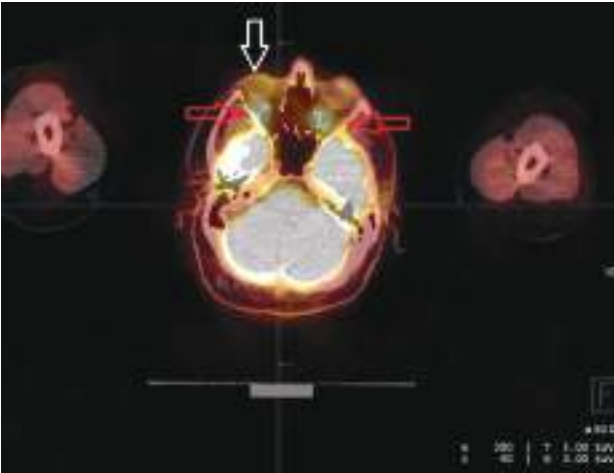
On post-radiotherapy Fluorodeoxyglucose positron emission tomography/Computed Tomography, the previously noted focal FDG uptake is no longer visible (white arrow), while symmetric retrobulbar FDG uptake, representing physiological uptake, is still observed (red arrows) (SUVmax up to 7.7)
